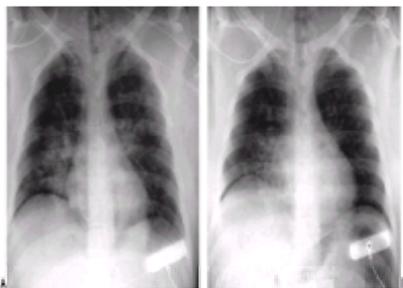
Freshwater near-drowning. (a) Portable anteroposterior chest radiograph within hours of presentation. Note less extensive infiltrates than in Fig. 1a in the right and left midlung zones as well as reduced lung volumes. (b) Ten hours later. Note improvement of infiltrates with some residual RLL density and further loss of lung volumes.
